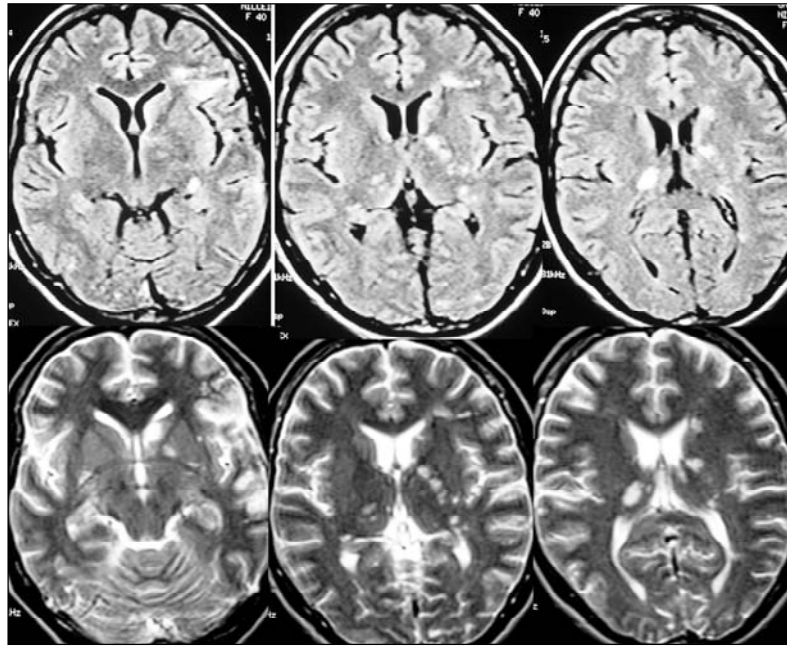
Magnetic resonance in FLAIR and T2 sequences, showing multiple areas of cerebral embolism.
